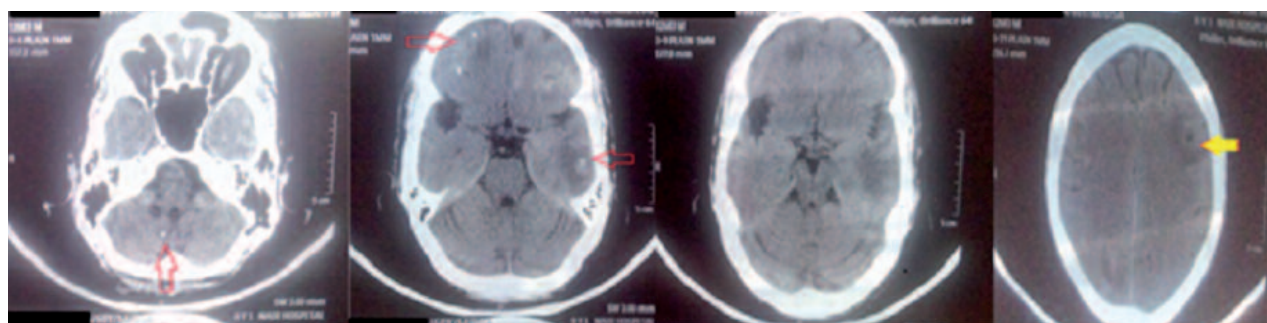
Plain Computed tomography of brain axial section showing multiple calcified lesions (red arrows) in the right frontoparietal, left temporal and right cerebellar hemispheres. A hypodense lesion (yellow arrow) with eccentric hyperdensity and perilesional edema is seen in the left frontal lobe.
